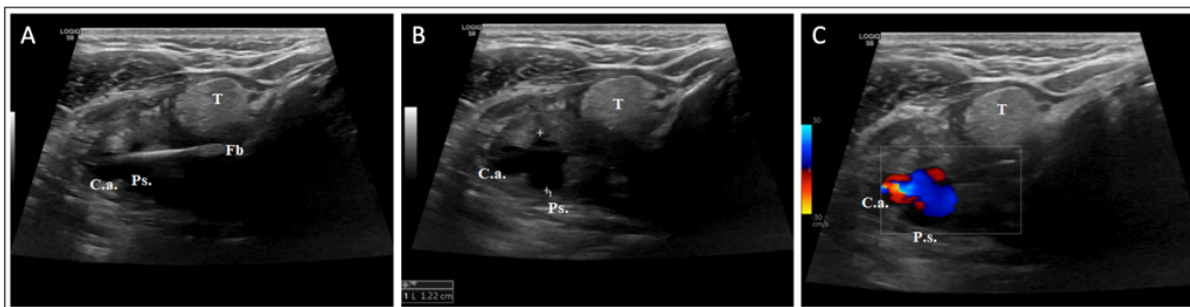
Neck B-mode ultrasound. (A) Paraxial view using a high-resolution multifrequency linear probe (bandwidth 3-12 MHz). The fish bone passes from the soft tissue posterior to the right lobe of the thyroid to the common carotid artery, where it forms a pseudoaneurysm at the site of entry. A foreign body is seen as a hyper-echoic linear structure within the common carotid artery. Ultrasound machine: Logiq S-8, General Electric, Milwaukee. (B and C) Axial ultrasound view in B-mode (B) and B-mode color Doppler (C) showing a pseudoaneurysm on the medial side of the right common carotid artery. T: thyroid gland; Fb: foreign body; Ps: pseudoaneurysm; C.a.: common carotid artery.
